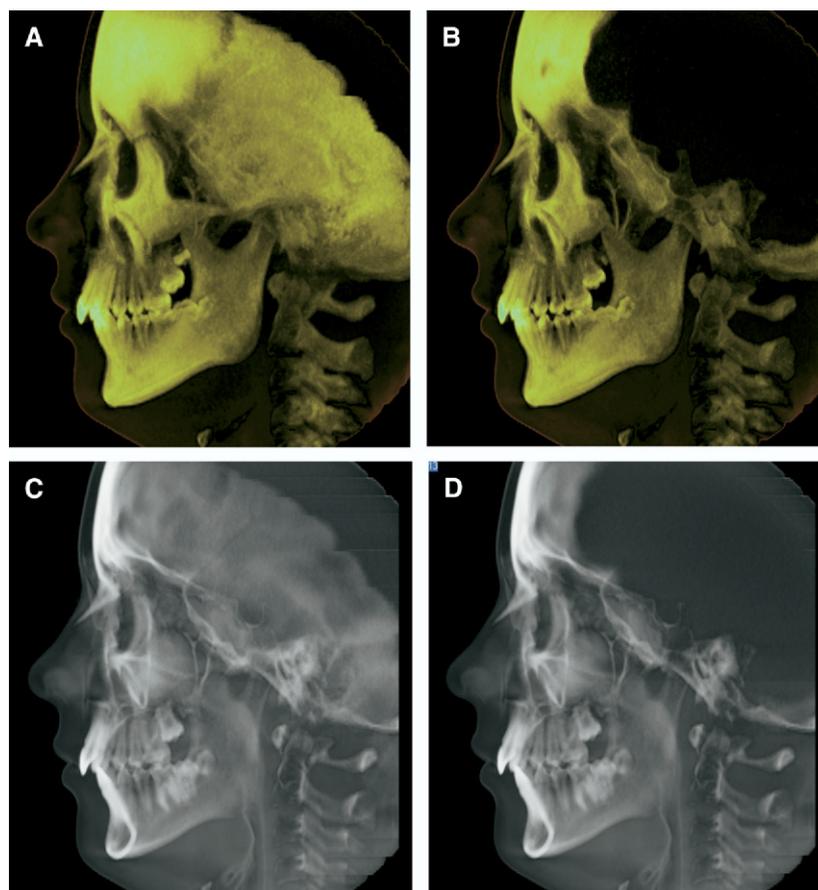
CBCT-synthesized lateral cephalograms: A and B, the MIP technique; C and D, the RayCast technique. In B and D, the left part of the skull and the right parietal bone are virtually excised, and only the right part of the skull is represented.
